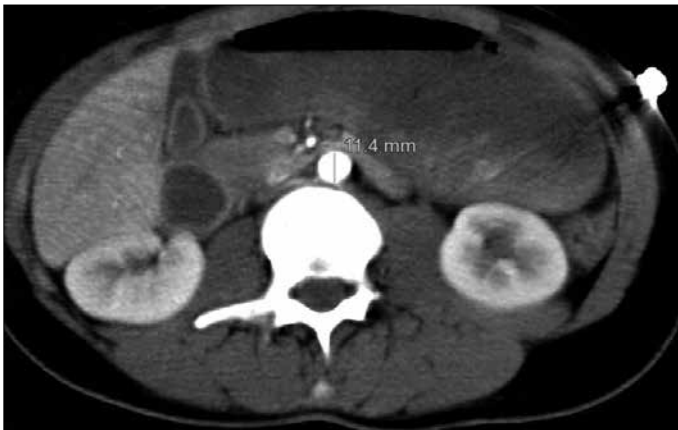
Low-calibrated abdominal aorta is seen in axial CT image. It must be less than 13 mm in measurements performed 2 cm below and above the renal arteries (3)
